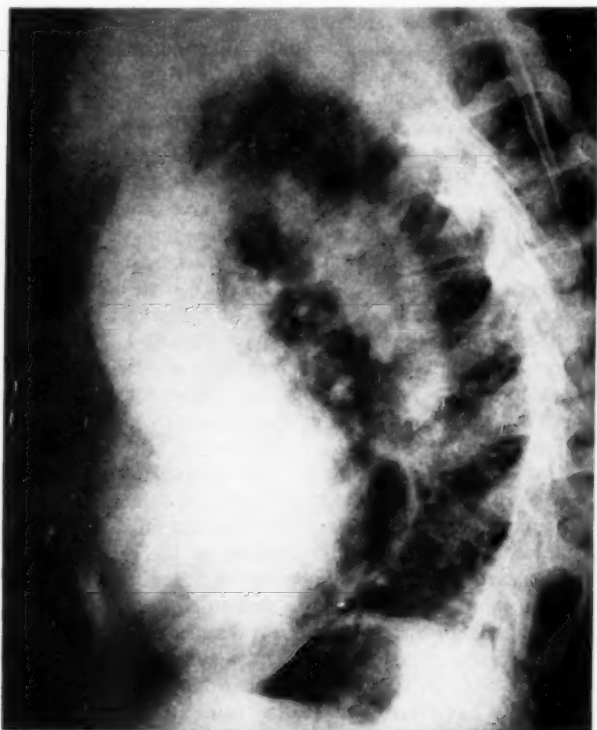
Coarctation of the Aorta*. Male, 54. Recurrent cardiac failure for six years. Classical physical and roentgen signs of coarctation of aorta. Blood pressure in arms 170/80; in legs 110/49. Rib notching present. *Left anterior oblique angiogram*. Aorta opacified. Note coarctation 2.5 cm. distal to origin of left subclavian artery. Dilated ascending aorta is seen, as are prominent internal mammary arteries anastomosing with superior epigastric arteries.
